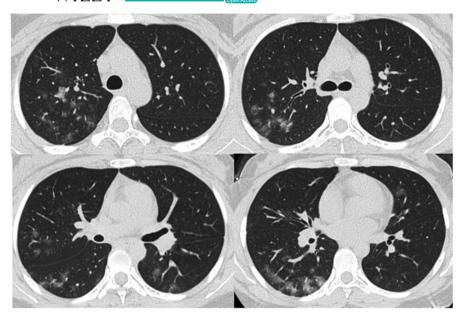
Chest computed tomography showing bilateral multiple ground glass opacities with subpleural and peribronchial distribution
